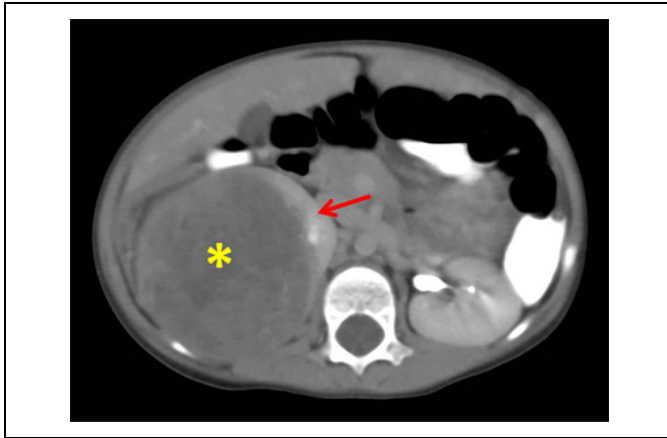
A computed tomography (CT) scan shows a large mass (*) on the right side with the remaining kidney (arrow) showing the “claw sign” around the mass, indicating that is likely of renal origin.
